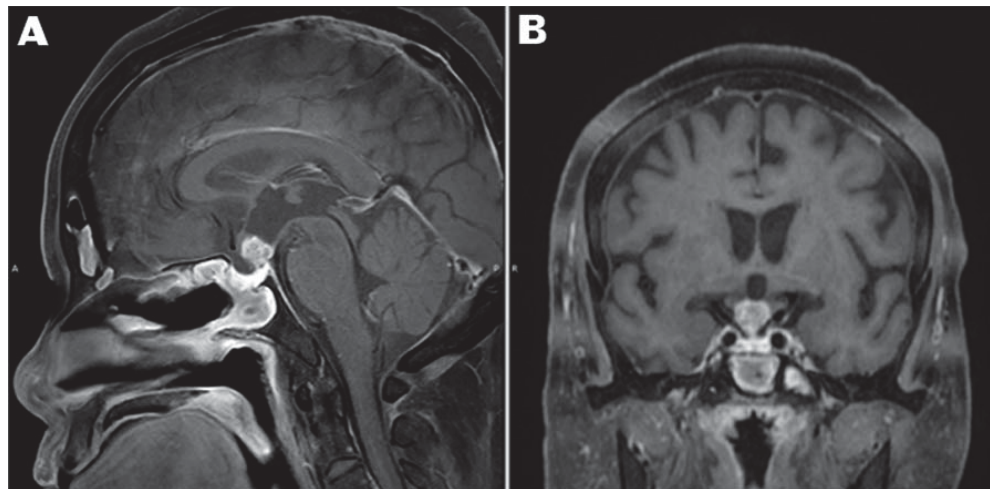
Contrasted T1-weighted magnetic resonance imaging, sagittal (A) and coronal (B), scans of the patient, at six months after treatments of the pituitary metastasis (PM), demonstrating shrinkage of the PM.
